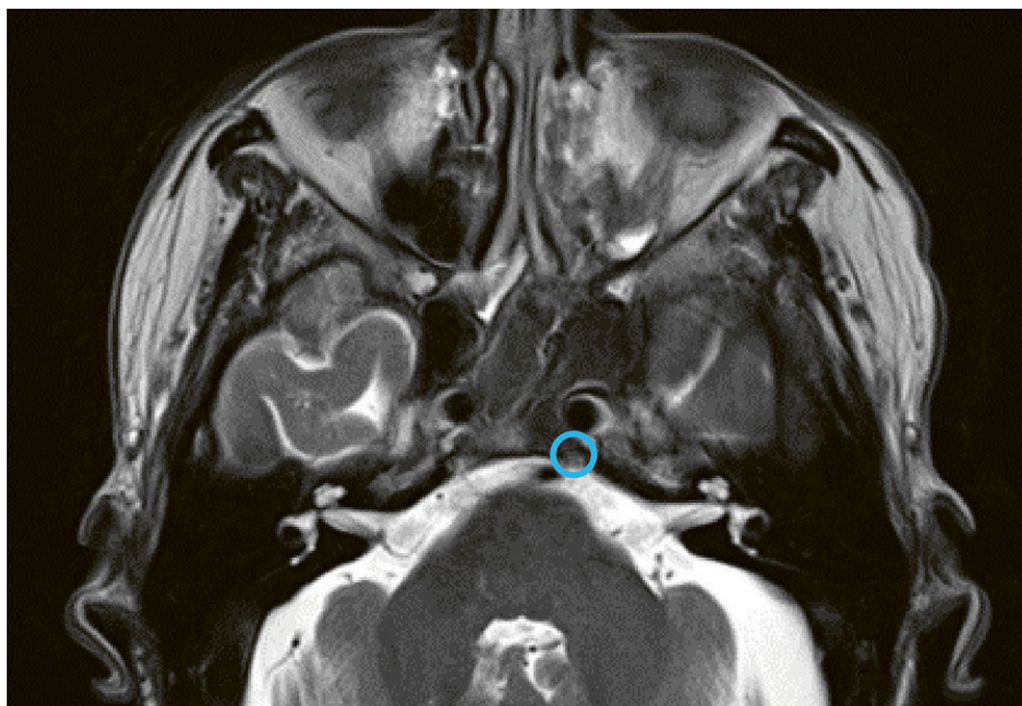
Axial T2-weighted MRI of the head showed no cerebral or intracranial pathology but demonstrated low signal intensity in the left sphenoidal sinus. In combination with the clinical picture and CT findings, this raised suspicion of fungal sinusitis. The circle around the entrance
